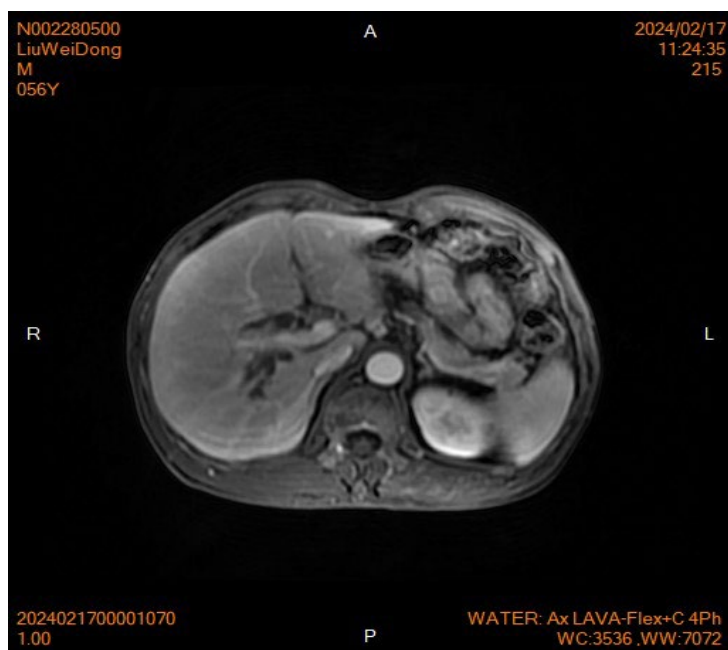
MRI demonstrates: thickening of the bile duct wall and luminal stenosis in the hepatic hilar region
